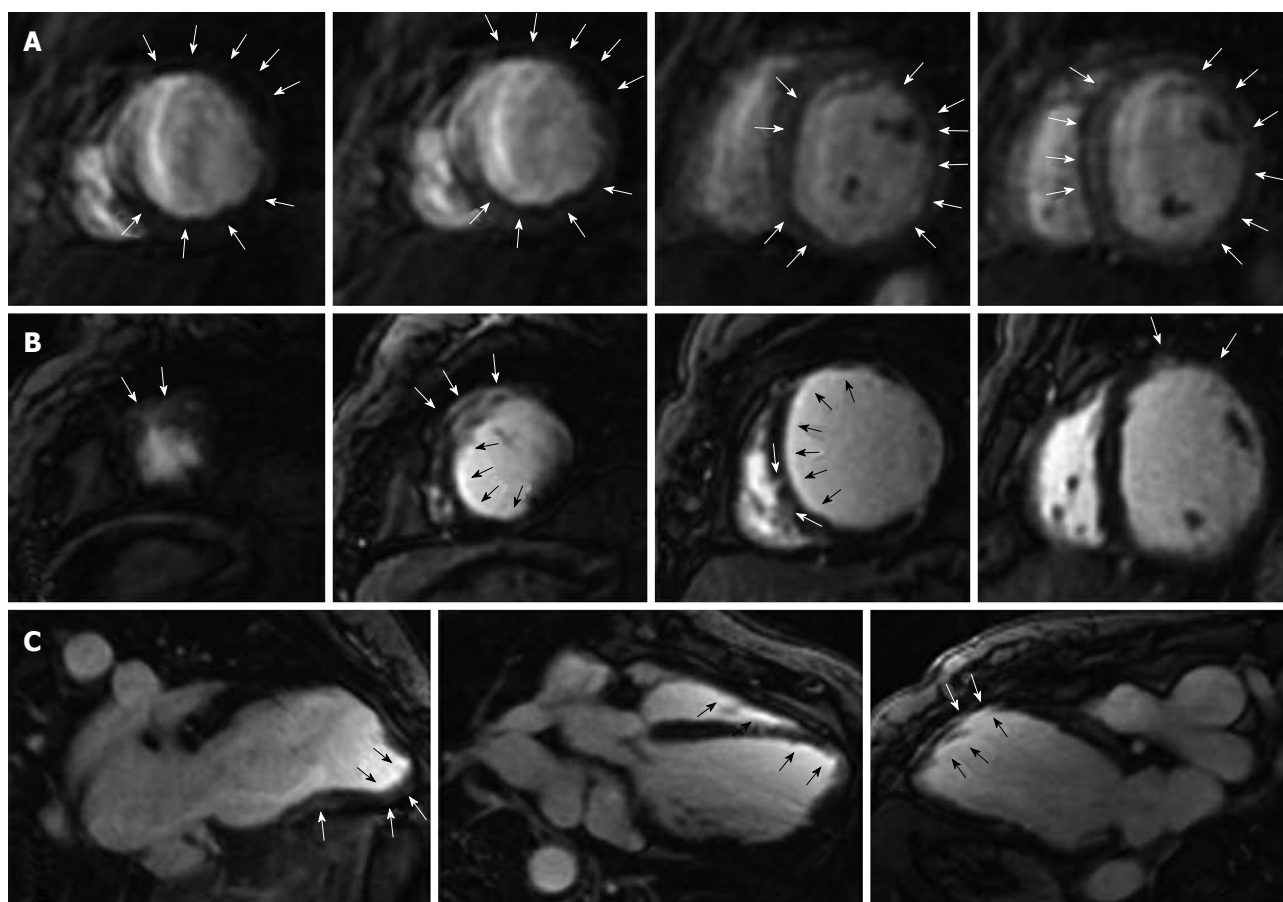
Cardiovascular magnetic resonance imaging. A: Images of the myocardium at peak myocardial enhancement during the first pass of gadolinium shows the perfusion defect (decreased perfusion) in the subendocardium of the mid-inferior wall, posterior-lateral wall, posterior-septal wall and anterolateral wall of the myocardium (white arrows); B, C: Delayed contrast-enhanced images show transmural hyperenhancement in the apical anterior, mid-anterior, mid-septum, basal-anterior wall (white arrows), and mid myocardial hyperenhancement in the inferior wall. The black arrows show delayed contrast enhancement in the subendocardium.
